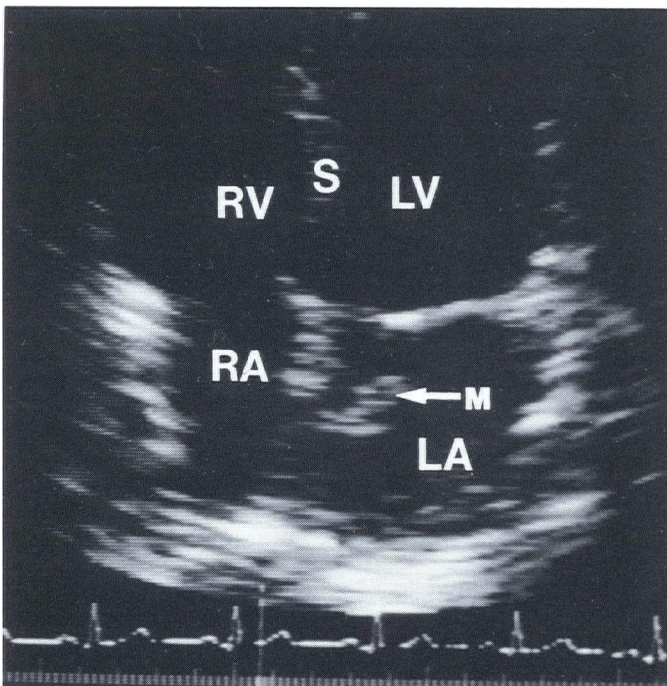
(Case 2)—Two-dimensional echocardiogram demonstrating the small pedunculated mass (arrow). (M = mass, LA = left atrium, LV = left ventricle, RA = right atrium, RV = right ventricle, S = interventricular septum.)
